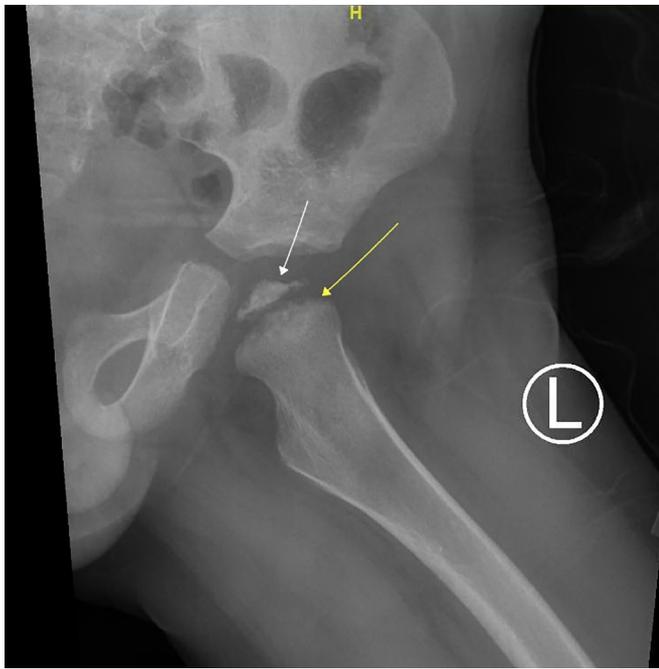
Left Femur X-ray. White arrow: Sclerotic femoral head with significant flattening. Yellow arrow: Sclerotic and irregular femoral neck
